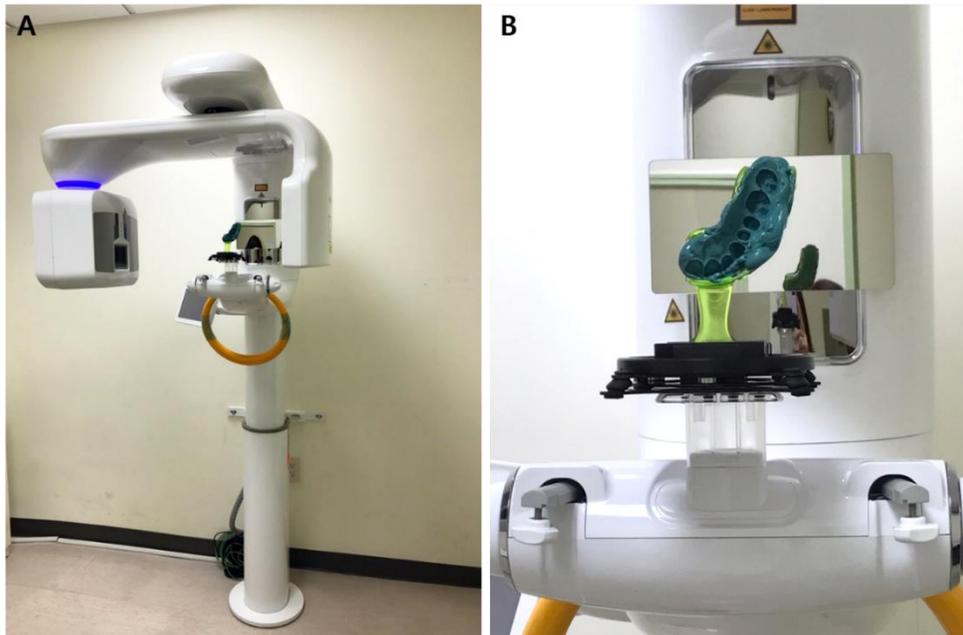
Cone-beam computed tomography scanning. A, CBCT apparatus (RAYSCAN α +); B, Fixating the impression on a special chin rest provided by the manufacturer to scan rubber impressions.
